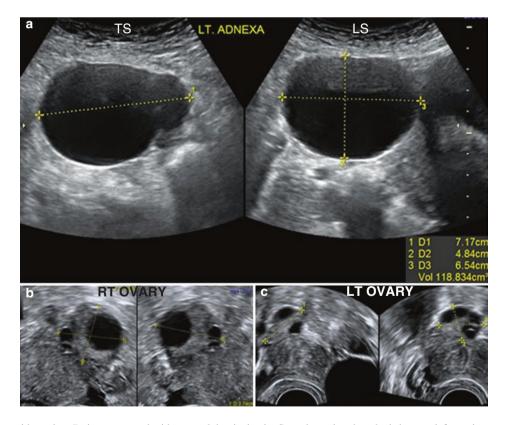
PO cyst with torsion. Patient presented with acute abdominal pain. Scan done elsewhere had shown a left ovarian septate cyst. (a) TAS shows a 118 cc anechoic cyst. (b,c) Normal right and left ovary seen separate from the cyst. (d) TVS shows an anechoic cyst with septae. (e) Cyst walls showing flow with an RI of 0.65. (f) Twisted pedicle of the torsed PO cyst is seen showing a whirlpool sign on greyscale and Doppler (*arrows*)
